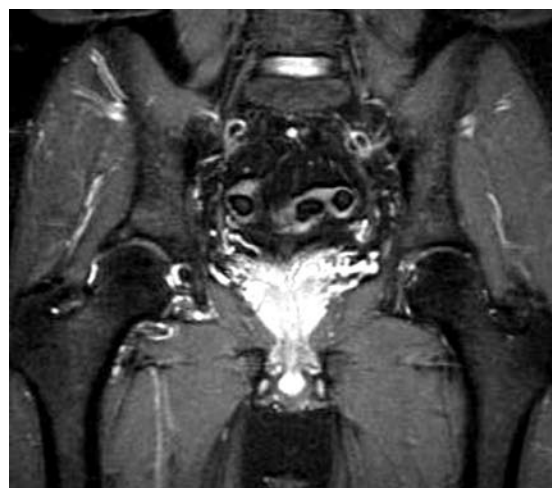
Coronal fat saturated T2-W MR image of the pelvis.
